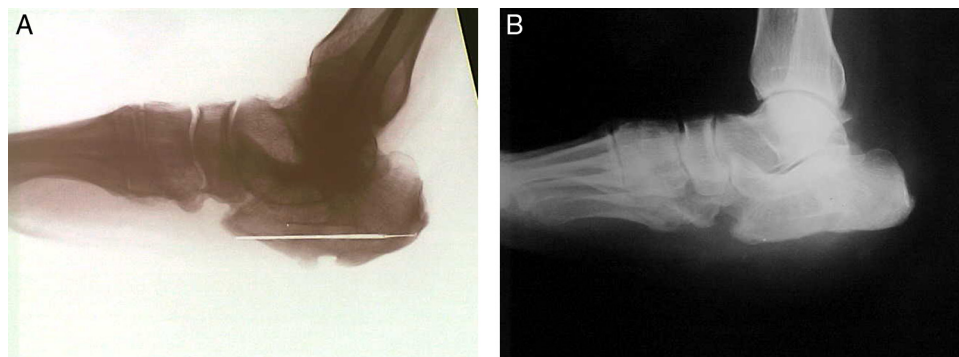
Lateral radiographs of the calcaneus. (A) Preoperative, with no evidence of osteomyelitis and areas of overpressure and (B) postoperative, highlighting the resection of the posteroinferior calcaneal tuberosity, correcting the deformities.
